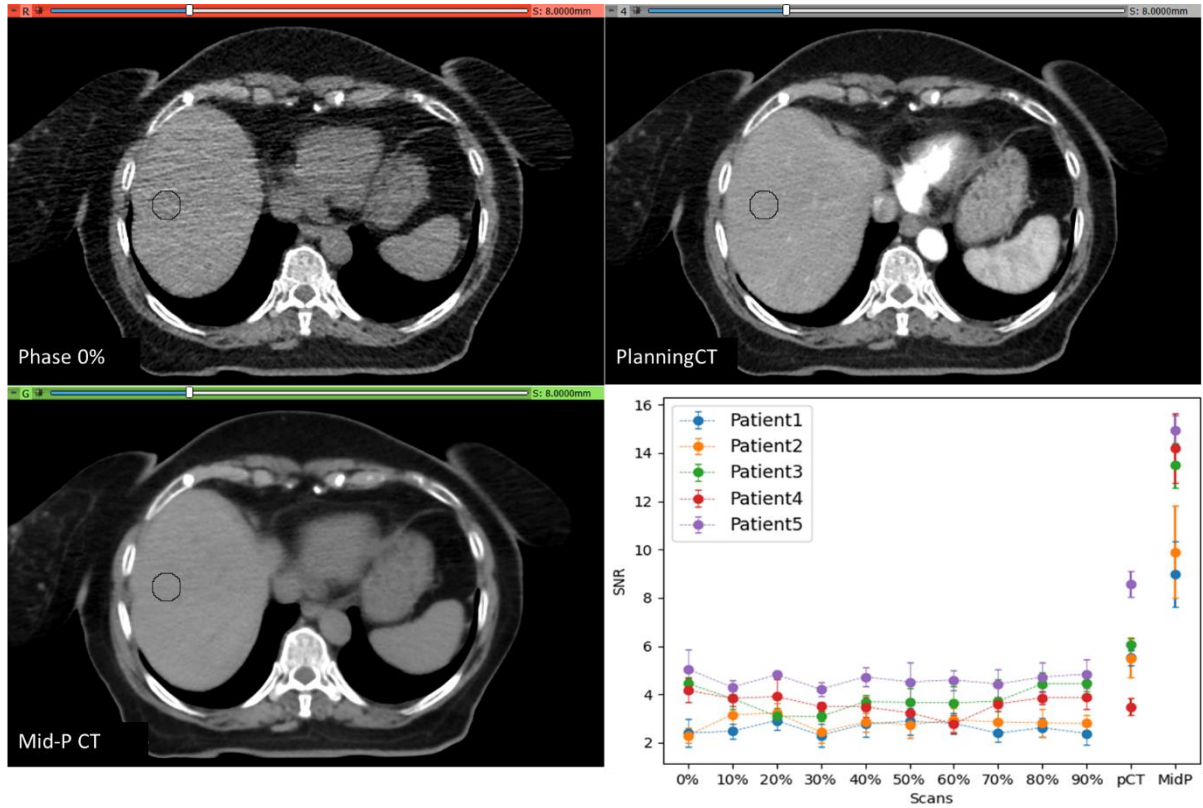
Axial slices from three different scans of Patient1: (A) one of the 4DCT frames (phase 0%); (B) the free-breathing planning CT; and (C) the Mid-P CT scan reconstructed by the *RunMidP* module. The SNR was calculated in each CT scan within circular ROIs in five adjacent slices in the liver, although only one ROI is shown in the image. (D) Mean and standard deviation of the SNR in homogeneous regions of the liver in ten 4DCT frames, in the free-breathing planning CT and in the Mid-P CT scan for the five patients in Study C. A reduction of the noise in the Mid-P CT scan compared to the planning CT and each frame of the 4DCT scan is clearly shown in the liver as well as in other organs.
